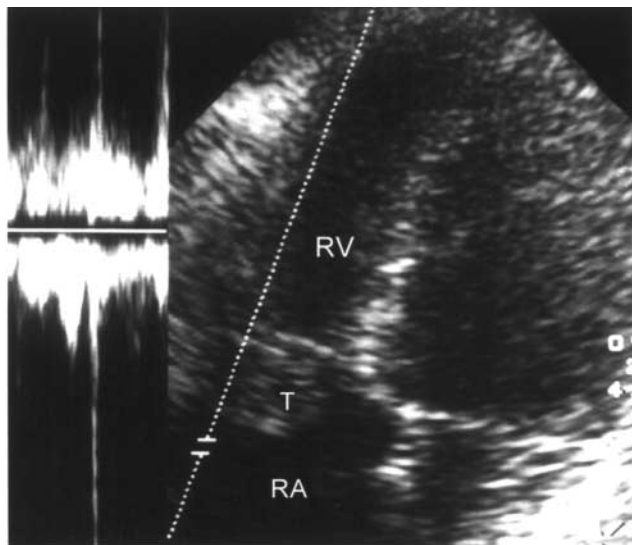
Echocardiogram showing pedunculated right ventricular lateral wall mass prolapsing through tricuspid valve. RA=right atrium; RV=right ventricle; T=tumour mass
